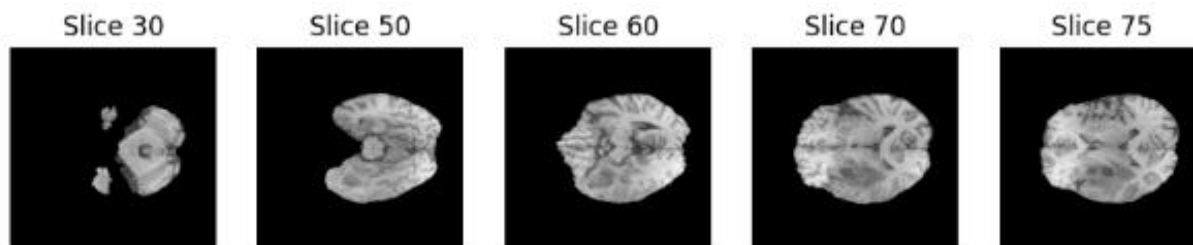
Axial slice extraction from 3D MRI volume
